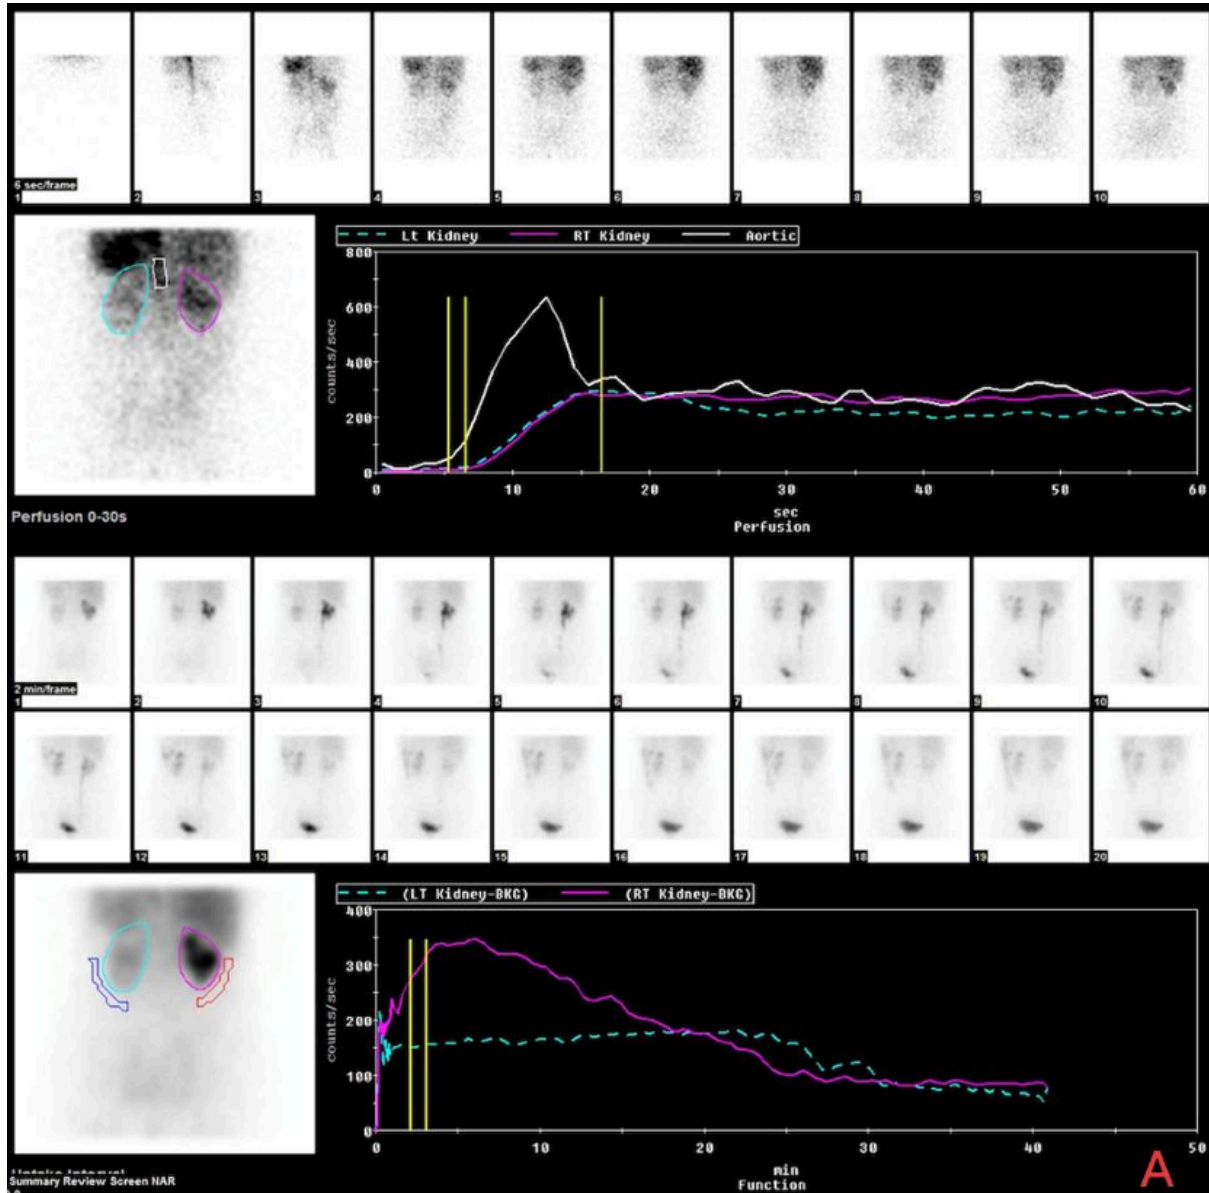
(A) Renal scintigraphy with Tc-99m MAG3 shows impaired perfusion and tubular function of the kidneys, particularly in the left kidney, characterized by a delayed perfusion phase compared to the aortic curve, decreased uptake, and slowed excretion. This pattern is consistent with an inflammatory renal process (pyelonephritis). No significant urinary tract obstruction is observed. (B) An accumulation of radio-pharmaceutical appears in the left upper quadrant abdomen from the intermediate phases of the examination with progressive increment in intensity. The findings suggest a suspicion of a fistula between the urinary system and other organ in the left hemi-abdomen
